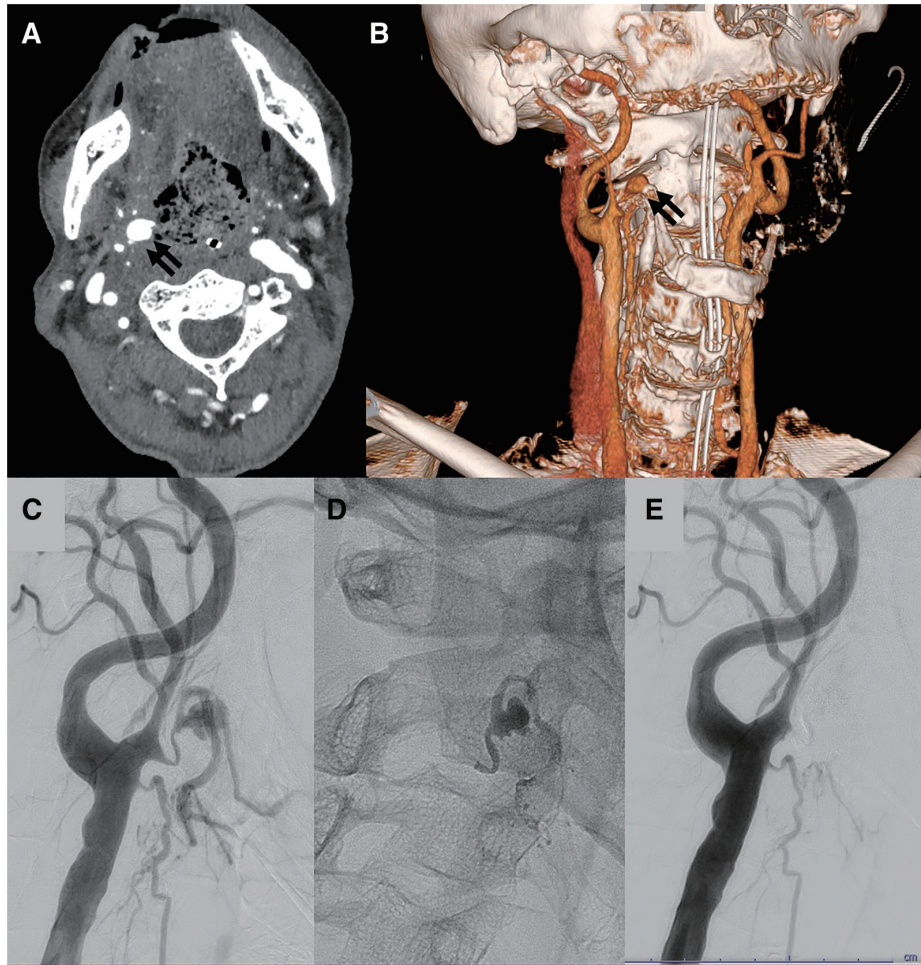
A case of lingual artery pseudoaneurysm embolization. The patient was a man in his 60s who had undergone chemoradiation therapy for pharyngeal cancer. He was referred to our hospital due to recurrent oral bleeding. (A) Contrast-enhanced CT of the neck, axial view. (B) 3D reconstruction. A pseudoaneurysm (A and B, black arrows) at the proximal portion of his right lingual artery was suspected as the cause of bleeding, and endovascular embolization was performed. (C) Right common carotid angiography pre-embolization, lateral view. (D) The aneurysm is embolized with the parent lingual artery using 33% NBCA. (E) Common carotid angiography post-embolization. The aneurysm completely disappears. NBCA, N-butyl cyanoacrylate
